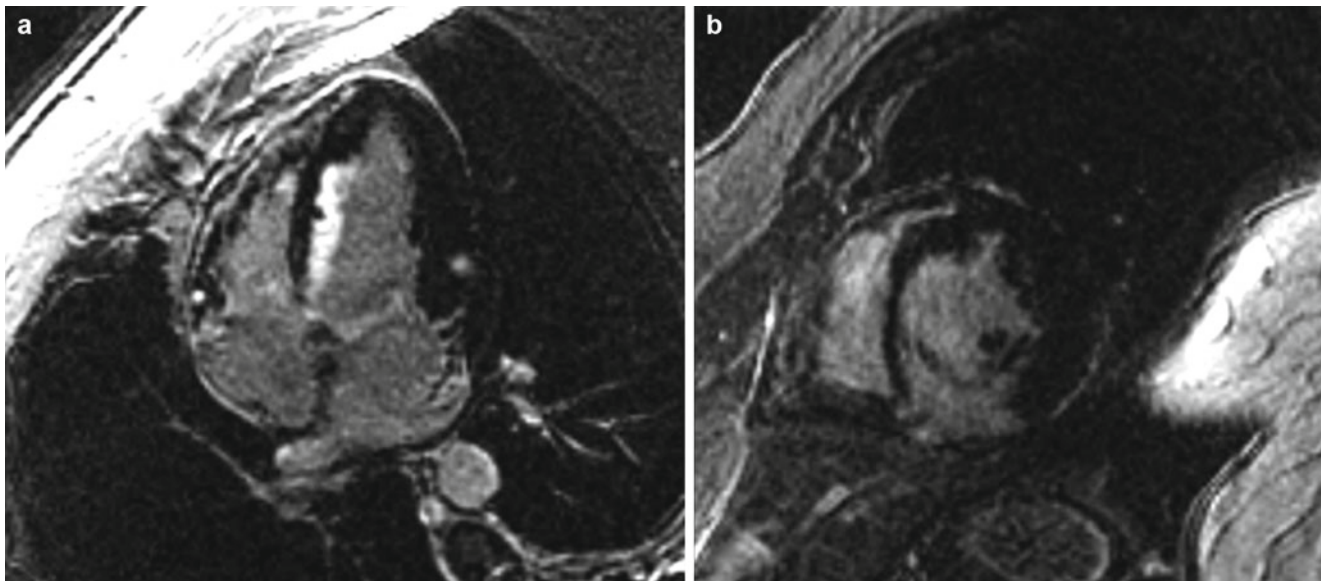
DE-MRI images of a 52-year-old male with a known history of apical hypertrophic cardiomyopathy who had none of the traditional risk factors for sudden cardiac death. Maximal wall thickness was 16 mm. While on a routine business trip, he collapsed at the airport.
